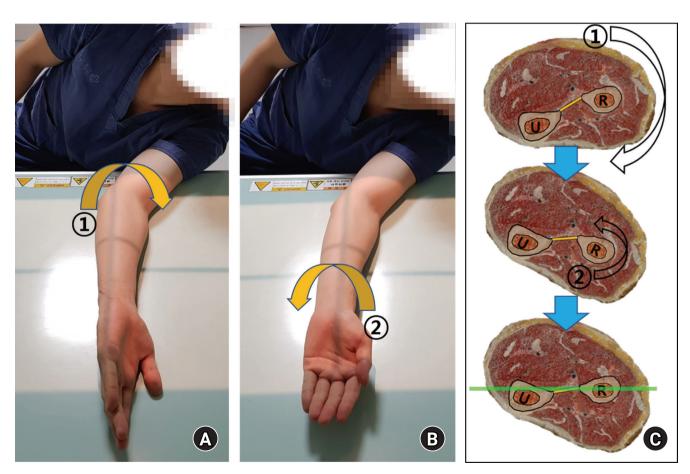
Palm-up oblique view radiography method. The patient is seated, initially placing the forearm on the cassette in the same position as a conventional 45° external oblique view (A), then asked to rotate only the forearm internally until the palm faces up (B). This method aligns the interosseous crests of both bones with different projections into the same plane for imaging (C). U: ulna, R: radius.
